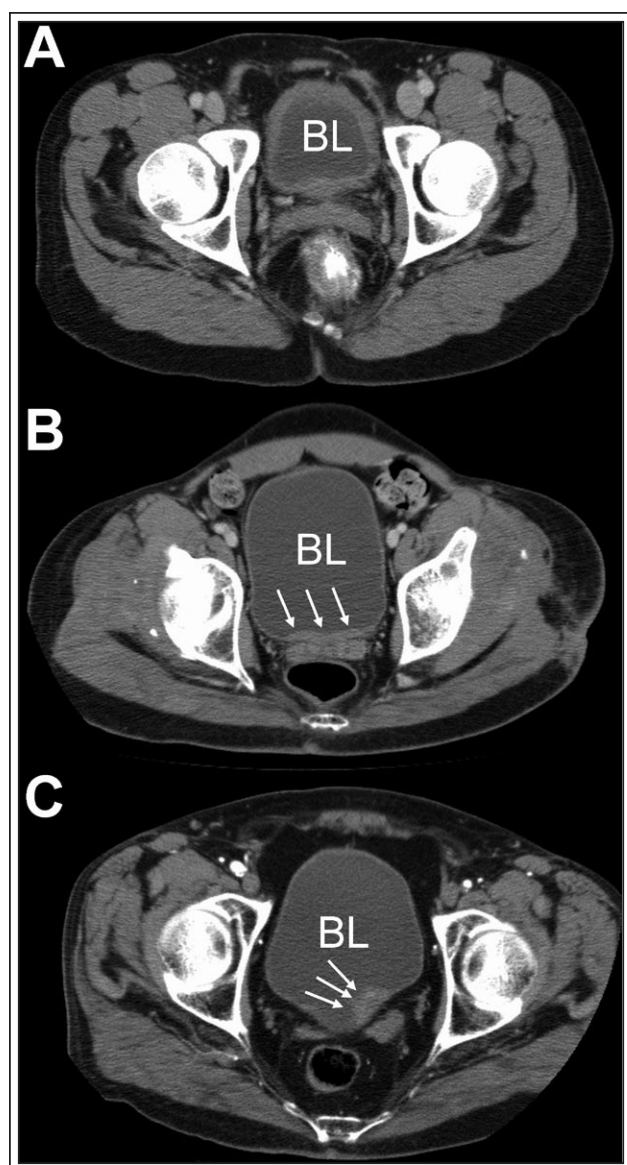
Examples of contrast-enhanced axial CT images through the pelvis demonstrating a) diffuse BWT, b) focal BWT and c) focal bladder mass from patients in the current study. Bladder is denoted by “BL”. Arrows in (b) point to an area of focal BWT, and arrows in (c) point to a focal bladder mass lesion.
